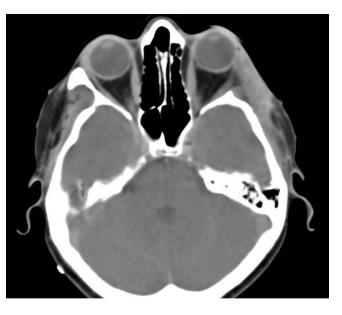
The CT scan with contrast enhancement shows that the masses in the left LG were totally cured.
